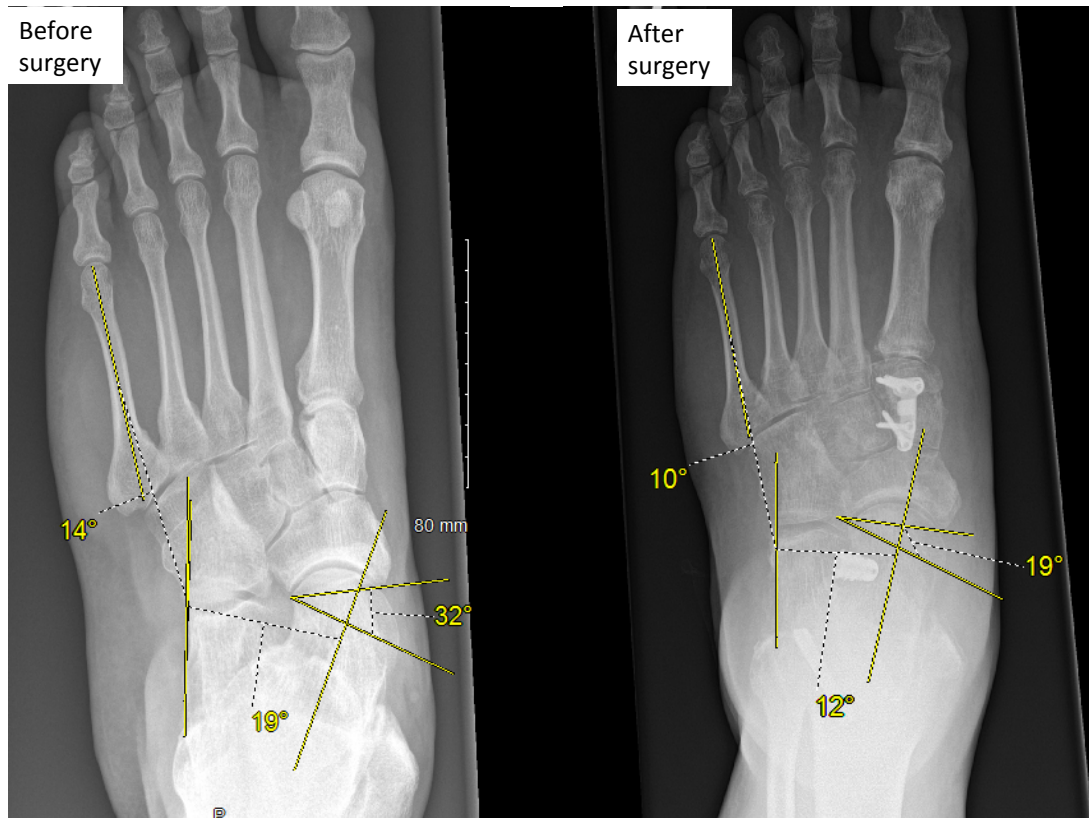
Dorsoplantar foot view before (left) and after (right) flatfoot reconstruction. The abduction of the forefoot is improved by 13 degrees (going from 32 to 19) when measured as talonavicular coverage angle and by 4 degrees (going from 14 to 10) when measured as calcaneus-fifth metatarsal angle. This apparent discrepancy between the two measurements (of 9 degrees) may find its explanation in the derotation of the subtalar joint with a change of the talocalcaneal angle of about 7 degrees (going from 19 to 12). The remaining unexplained rotation (approximately 2 degrees) is probably a consequence of two-dimensional radiographs biases (i.e. projection and operator-related biases), which reduce the accuracy of measurements.
